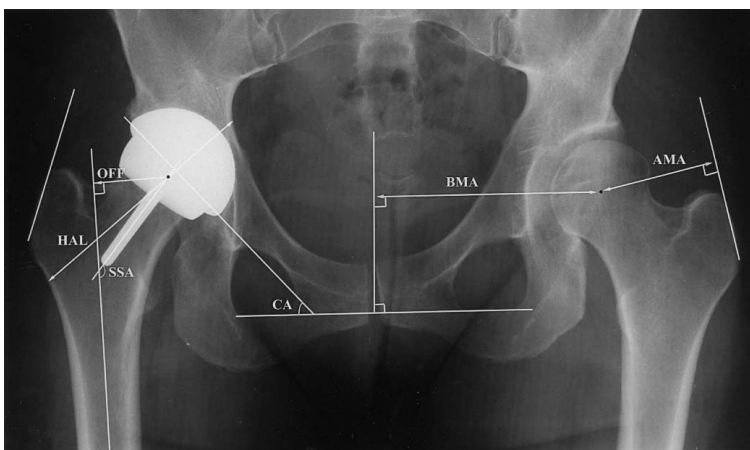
This radiograph shows the radiologic measurements for biomechanical analysis. OFF = femoral offset; HAL = hip axis length; AMA = abductor moment arm; BMA = body moment arm; CA = cup angle; SSA = stem shaft angle.
